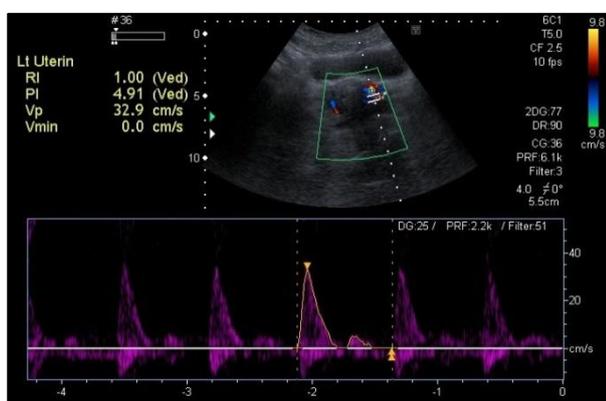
(b): Showing blood flow pattern and Doppler indices of Left uterine artery in a married female of 24 years with polycystic ovaries
